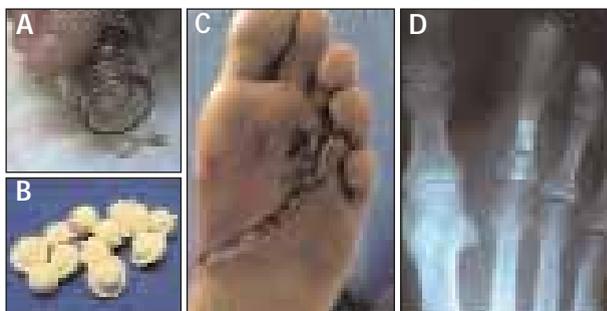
Antibiotic-impregnated calcium sulfate pellets (A,B). Notice the foot 4 days after insertion (C) and the beads on an x-ray (D).
